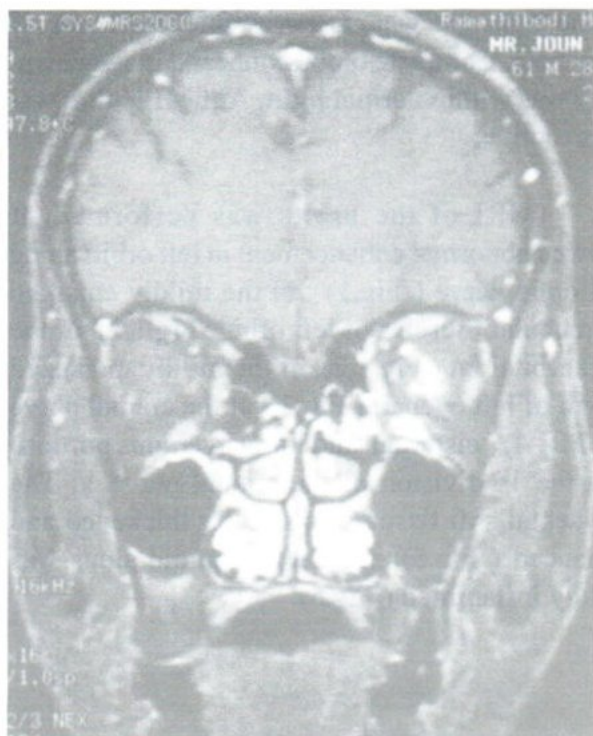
I.V. enhanced coronal MRI of the orbits showed abnormally increased enhancement of the mildly enlarged extraocular muscles of left orbit.
